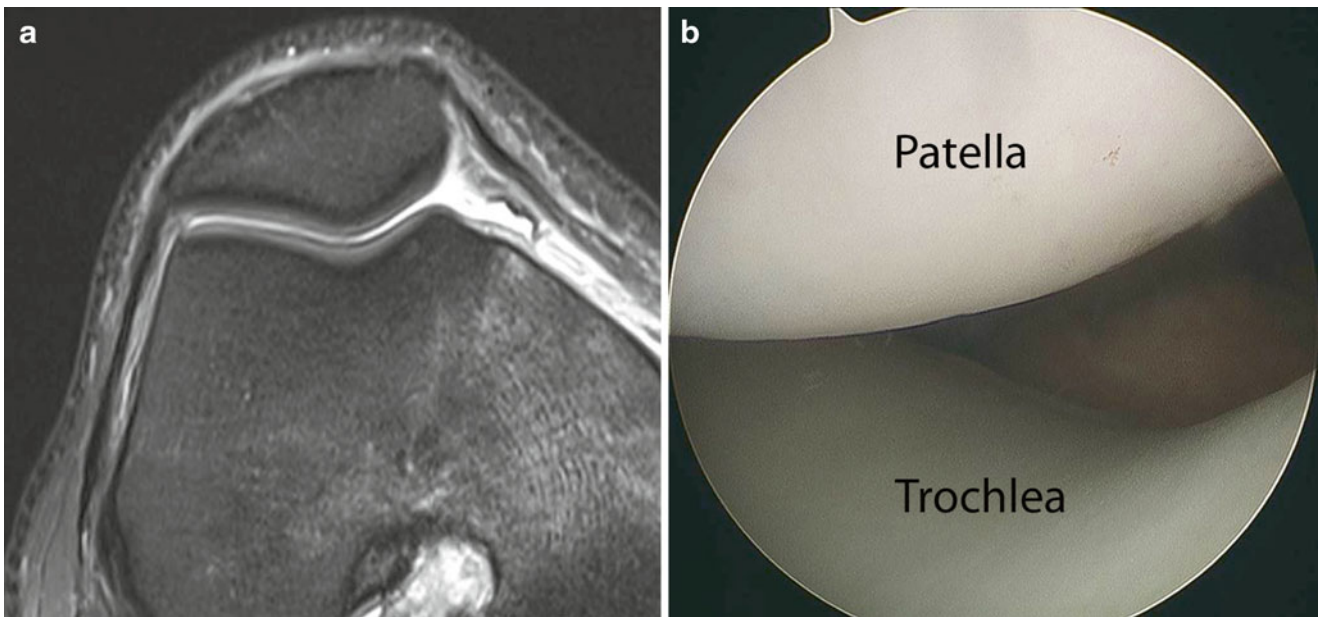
(a) An axial T2-weighted MRI image shows healthy cartilage of the patella and femoral trochlea as well as the congruence of the two. (b) Viewed from the anterolateral portal, the patellofemoral articulation is well visualized
